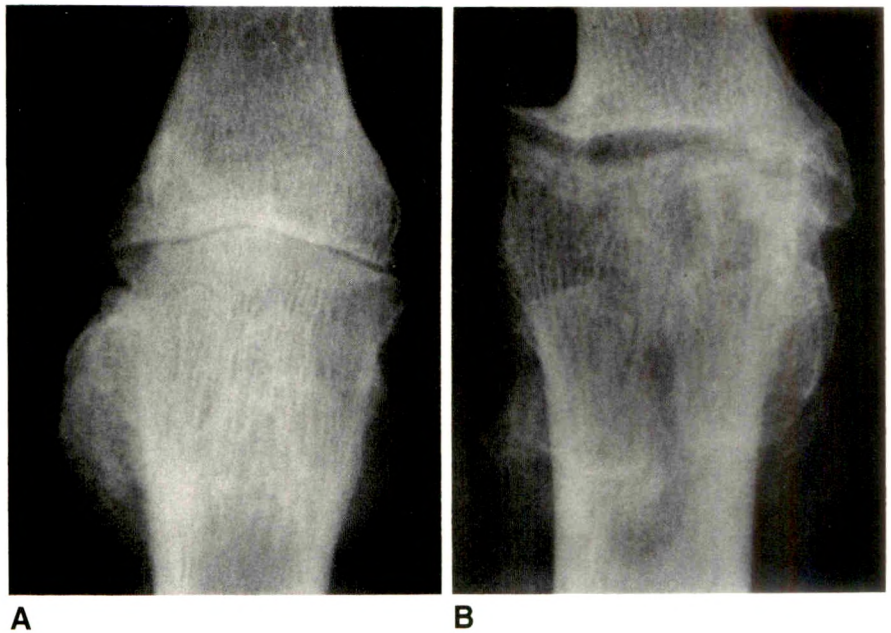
A and B, Dorsal ossicles with hallux rigidus. Lateral radiographs show dorsal ossicles (arrow) in conjunction with dorsal spurs of metatarsal head. Dorsal ossicles or intraarticular bone fragments result from repetitive micro-trauma or synovial chondrometaplasia.
